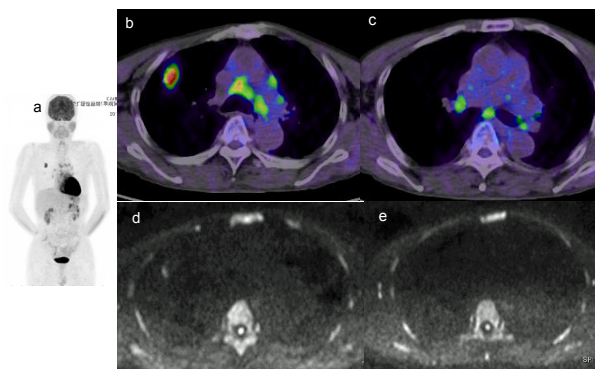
66 y.o. Male with Pulmonary Squamous Cell Carcinoma, but Without Lymph Node Metastasis. The patient was diagnosed as n2 disease by PET-CT, but n0 disease by DWI. DWI showed lymph node station #4R as negative (d), and lymph node station #7 as negative (e). The lymph nodes were diagnosed as pneumoconiosis pathologically
